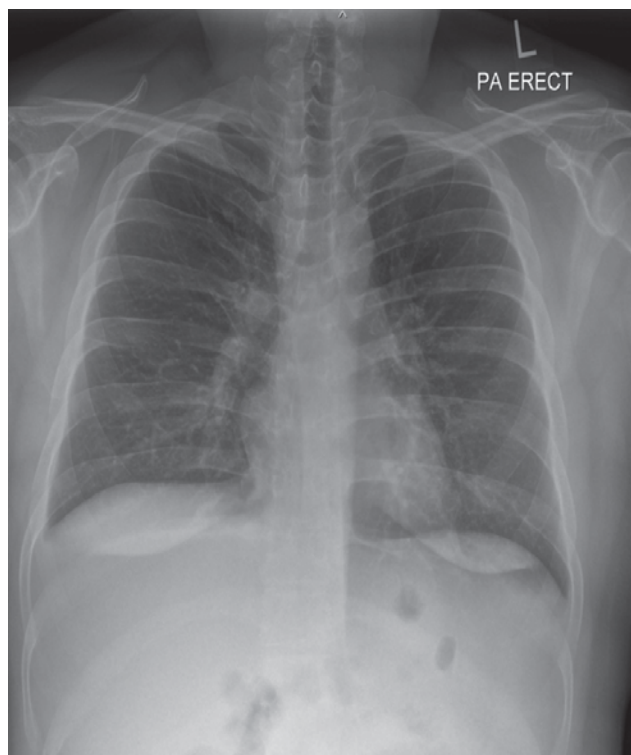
Initial Chest Radiography at the time of admission revealed only minimal obliteration of the right cardiophrenic angle, Minimal Pleural effusion on the right.
